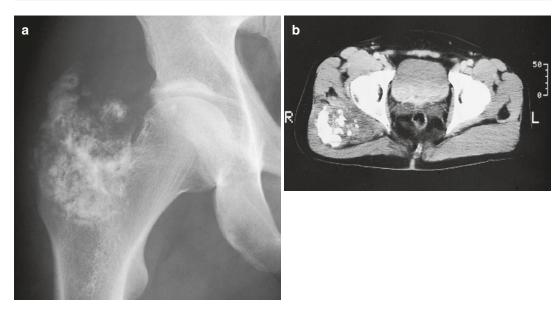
(a, b) Extraskeletal mesenchymal chondrosarcoma of the buttock in a 32-year-old man: (a) plain radiograph; (b) CT; large calcified mass superior to the trochanter major (a). CT reveals a soft tissue component medially and the calcified component laterally within the mass (b). Findings on plain radiography and CT are indicative of a lesion of cartilaginous origin
